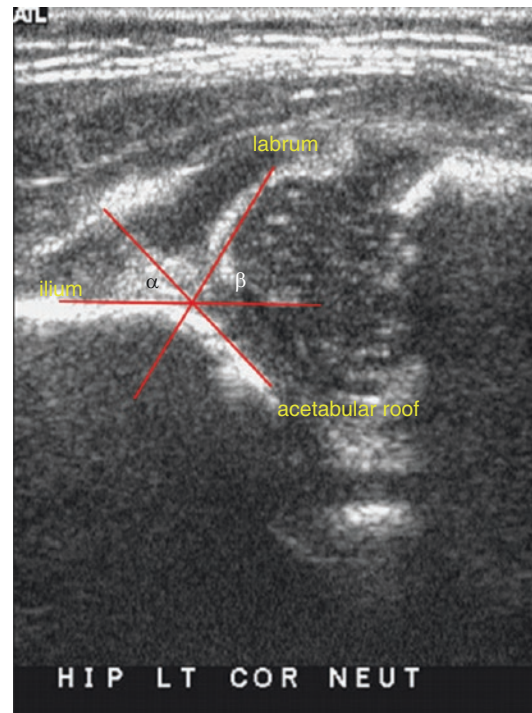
Coronal view of hip ultrasound showing the abnormal positioning of the femoral head and a decreased alpha angle in a subluxated hip
